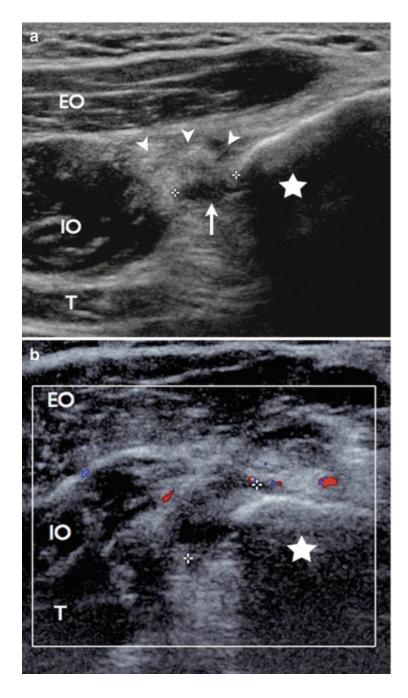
Transverse ultrasound image with a 17–5 MHz transducer at the level of iliac crest. (a) Grade 2 strain of the internal oblique muscle appears heterogeneous with hypoechoic bleeding (*arrow*) and surrounding hyperechoic edema (*arrowheads*). (b) Color Doppler shows peripheral hyperemia. *EO* external oblique, *IO* internal oblique, *T* transverse muscle
